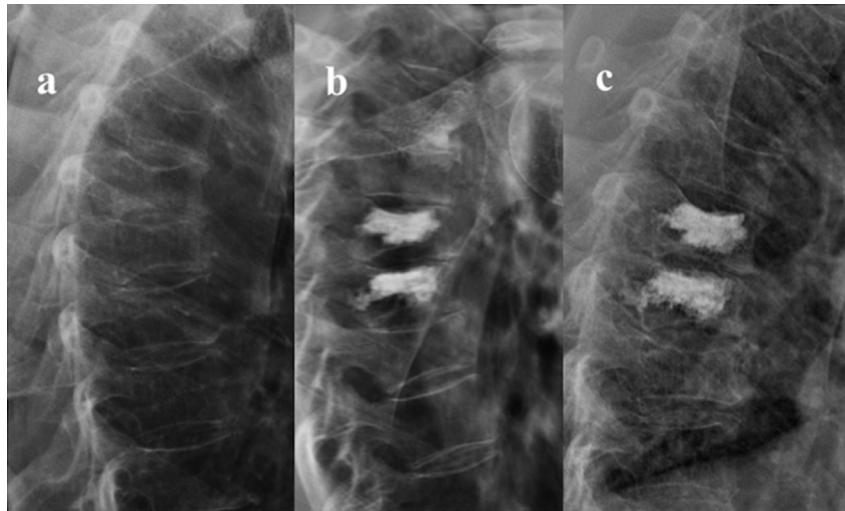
Lateral radiographies of a 72 years old female patient in whom augmentation of T6 and T7 vertebrae was performed with elastoplasty due to osteoporotic VCFs. a) preoperative, b) early postoperative and c) during the last follow-up.
